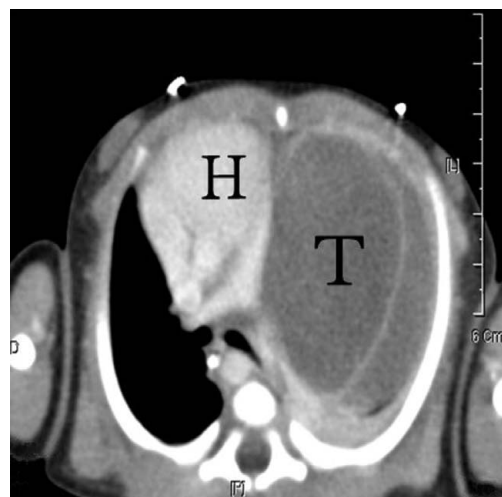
Chest and abdominal computed tomography shows a hypodense multiseptal tumor (T) in the left thoracic cavity with right-side-shifted heart (H) and trachea.
